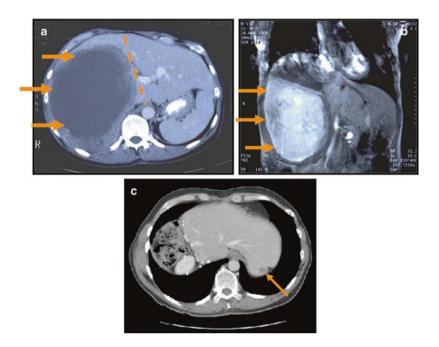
Preoperative CT scan of liver metastases from GIST (a, b). Contralateral recurrence at 6 months (c)
